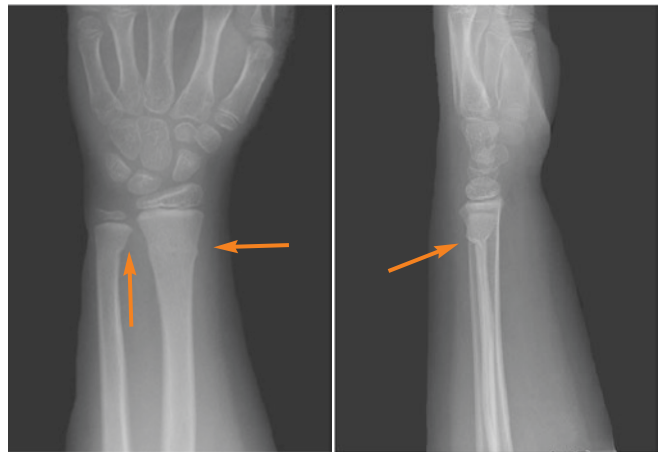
(a) Anteroposterior and (b) lateral X-rays of the wrist with a buckle fracture in the distal part of the radius and ulna (arrows)
